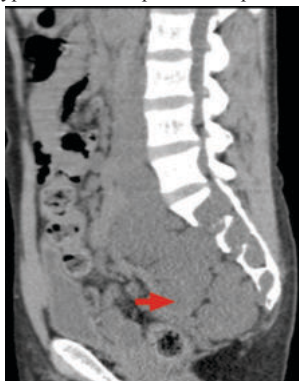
8 CT- sagittal section abdomen shows multi- lobulated hypo dense conglomerate mass seen extending into the pelvis with widening of sacral foramina.
